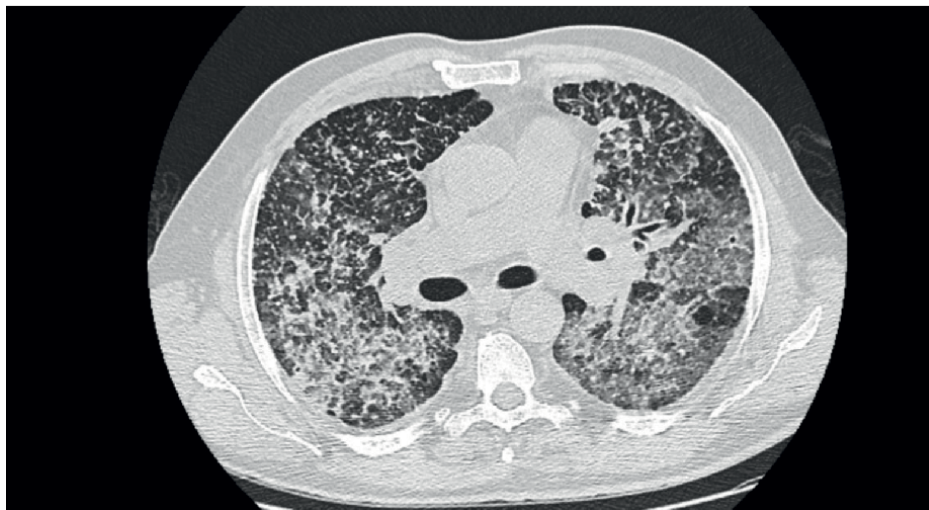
CT image in the axial plane demonstrates a generalized miliary pattern in both lung fields, with associated ground-glass areas showing a tendency to multifocal condensations.
